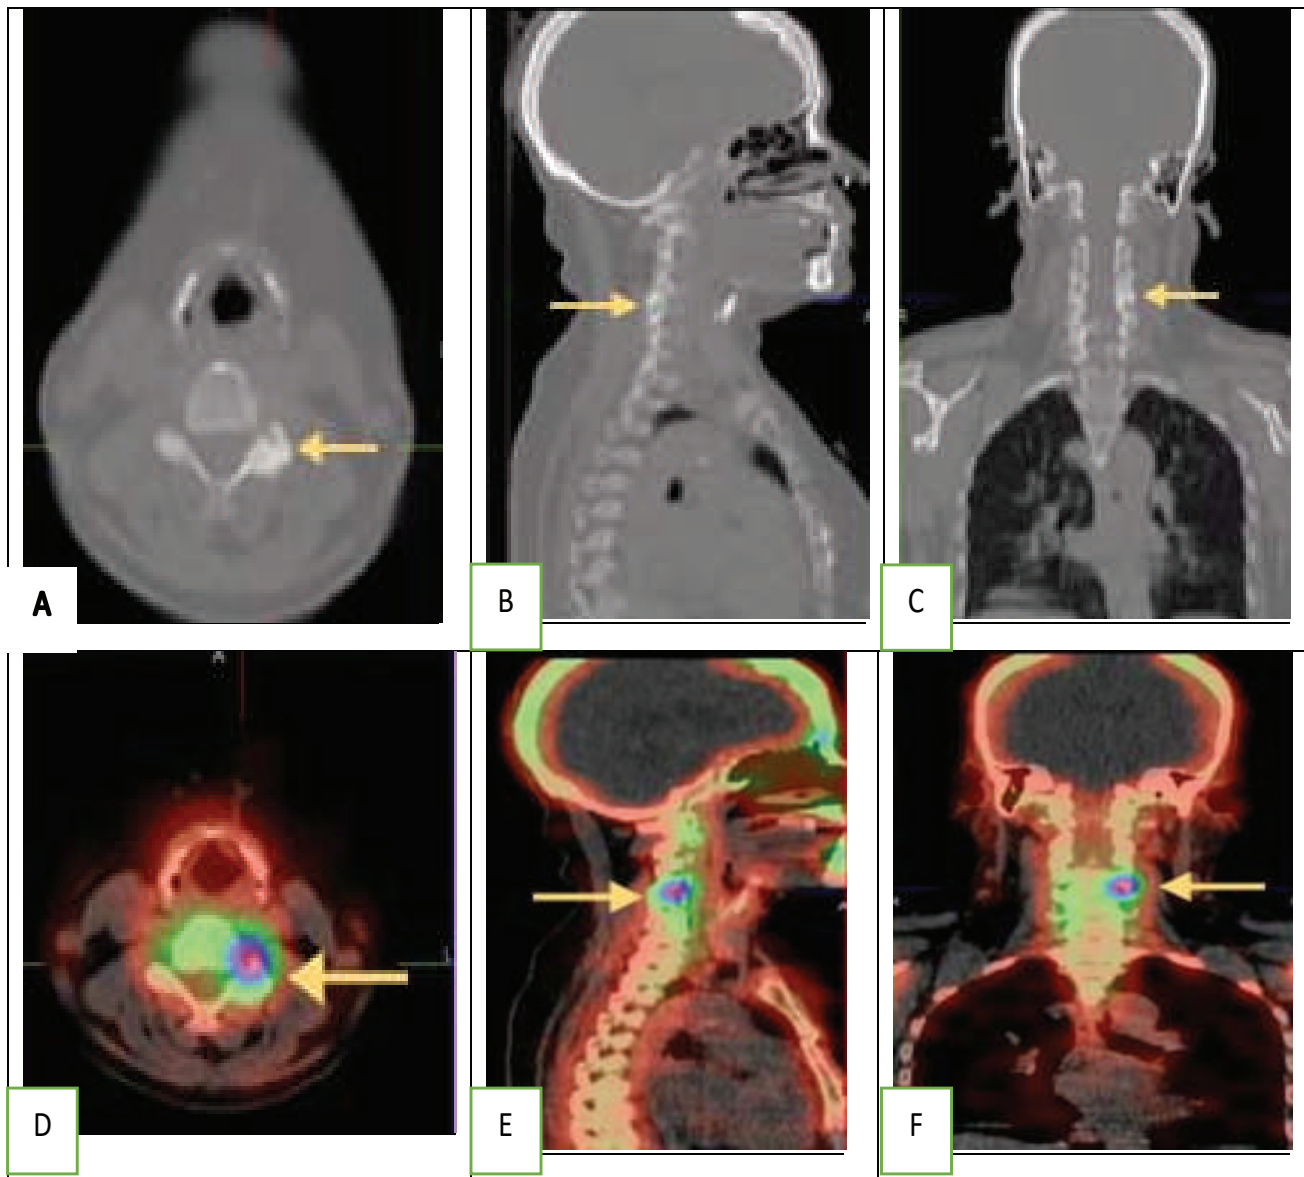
Axial (A), Sagittal (B), Coronal (C) CT image showing sclerotic change in right 5th cervical vertebra (yellow arrow). Fused SPECT/CT image of the same patient; Axial (D), Sagittal (E), Coronal (F) SPECT/CT images showing increase 99mTc-MDP uptake (yellow arrow) in the right 5th cervical vertebra corresponding to degenerative facet joint arthropathy.
